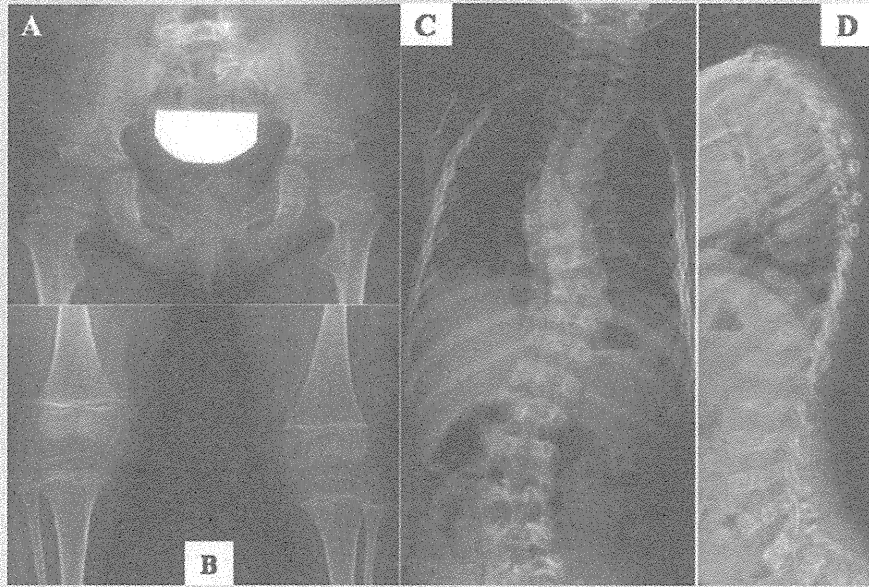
Radiographs of Patient 1 at age 4 years. A: Pelvis A-P. Flared and short ilia and horizontal acetabulum with supra-acetabular notches. The femoral necks are short and broad with mild metaphyseal irregularities. The femoral heads are ossified well. B: Knee A-P. Mild flaring of the metaphyses of the long bones. The epiphyses are spared. C,D: Anteroposterior [C] and lateral [D] projections of the spine. Scoliosis, marked platyspondyly with overfaced pedicles. These findings are compatible with spondyloepiphyseal dysplasia, Kozłowski type.
